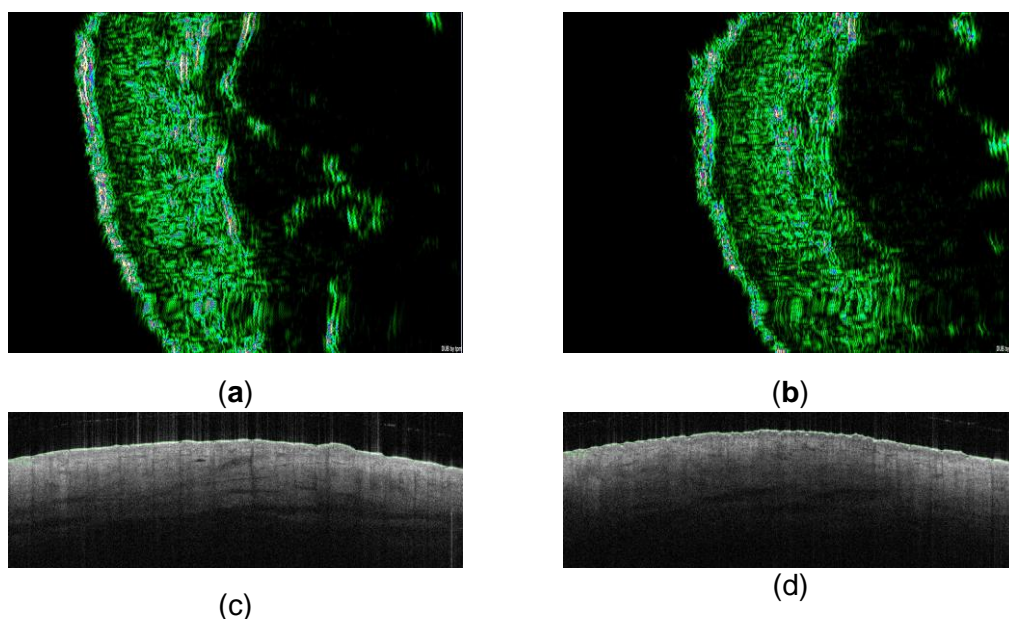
(a)High-resolution ultrasound image before SLS application; (b)High-resolution ultrasound image after SLS application; (c)OCT image before SLS application; (d)OCT image after SLS application.
